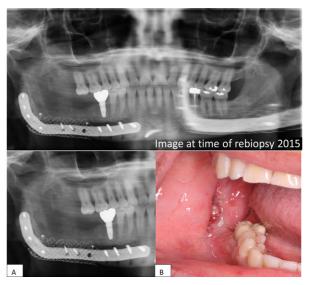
(A) Panoramic imaging at time of biopsy in 2015. Panoramic and cone beam computed tomography (not pictured) imaging of limited diagnostic value. (B) Clinical photo of soft tissue swelling, right buccal mucosa/retromolar pad region, at the 2-week follow-up appointment.
